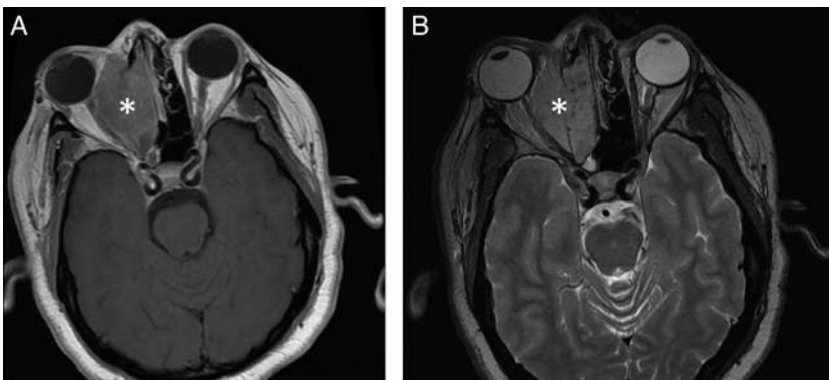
46-year-old woman was initially treated with antibiotics for presumed sinusitis. She underwent an MRI after acute right monocular vision loss and was found to have a right alveolar rhabdomyosarcoma. Axial T1-weighted noncontrast MRI demonstrates a T1 isointense mass involving the right ethmoid sinus and extraconal orbit extending into the orbital apex (A, white asterisk). Axial T2-weighted MRI demonstrates this mass to be T2 hyperintense (B, white asterisk). MRI indicates magnetic resonance imaging.
